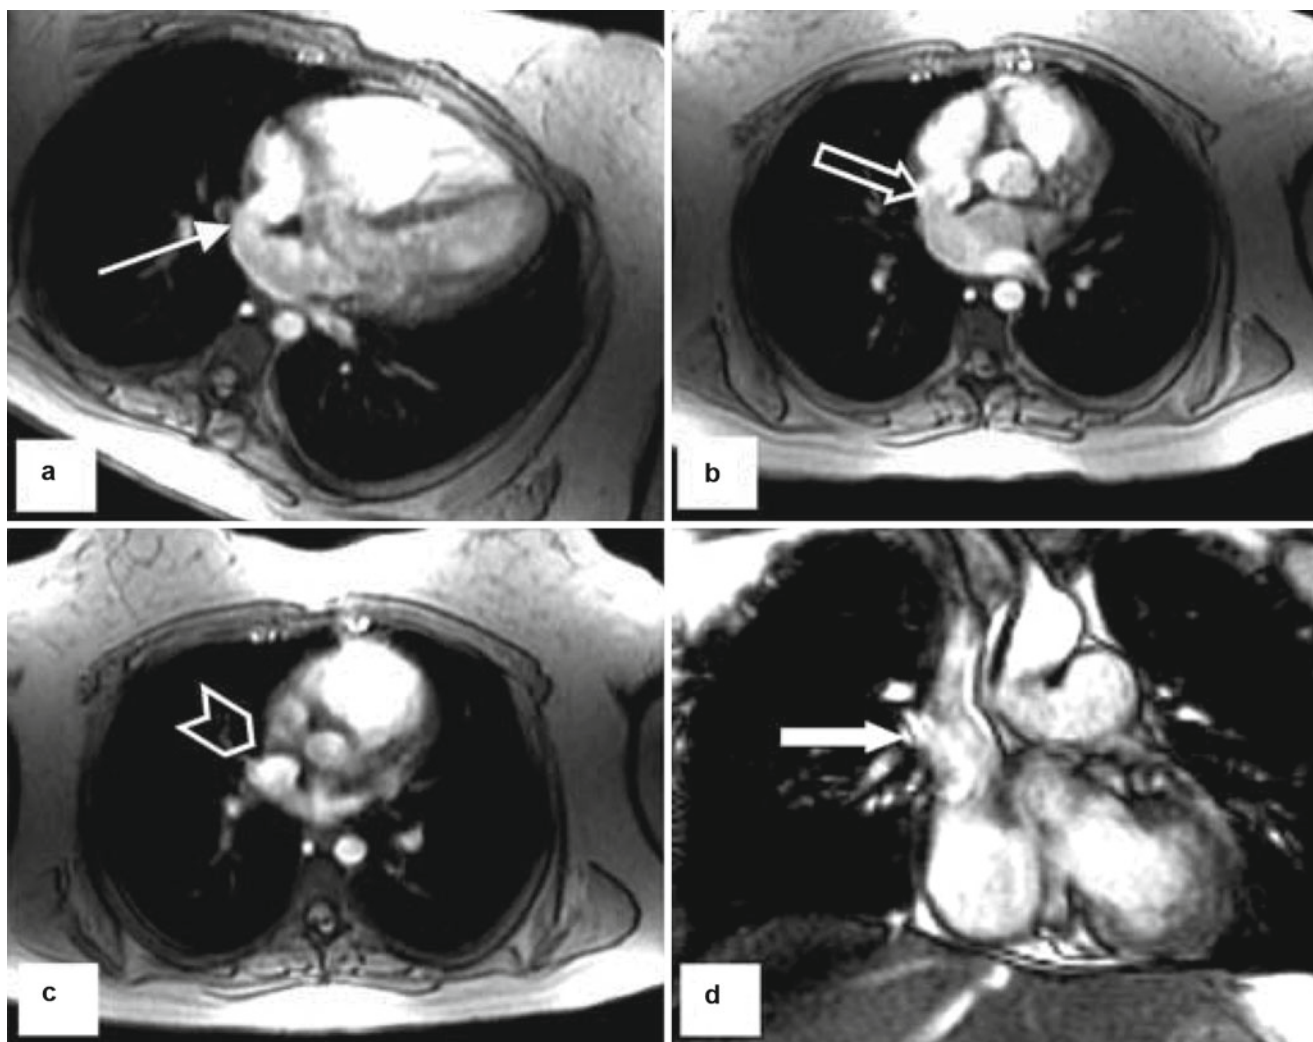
A 24-year-old female presented to the internal medicine clinic for establishment of routine care. A murmur was heard and an echo performed, demonstrating normal LV/RV size, no intracardiac shunt, and an atypical posterior RA signal by color Doppler, prompting a cardiac MRI. (a) Demonstrates an absent posterior inner atrial septum with flow saddling between the RA and LA. The “broken ring sign” is present in b (arrow) demonstrating the classic sinus venosus defect as a defect between junction of the low SVC and high RA, a less common
